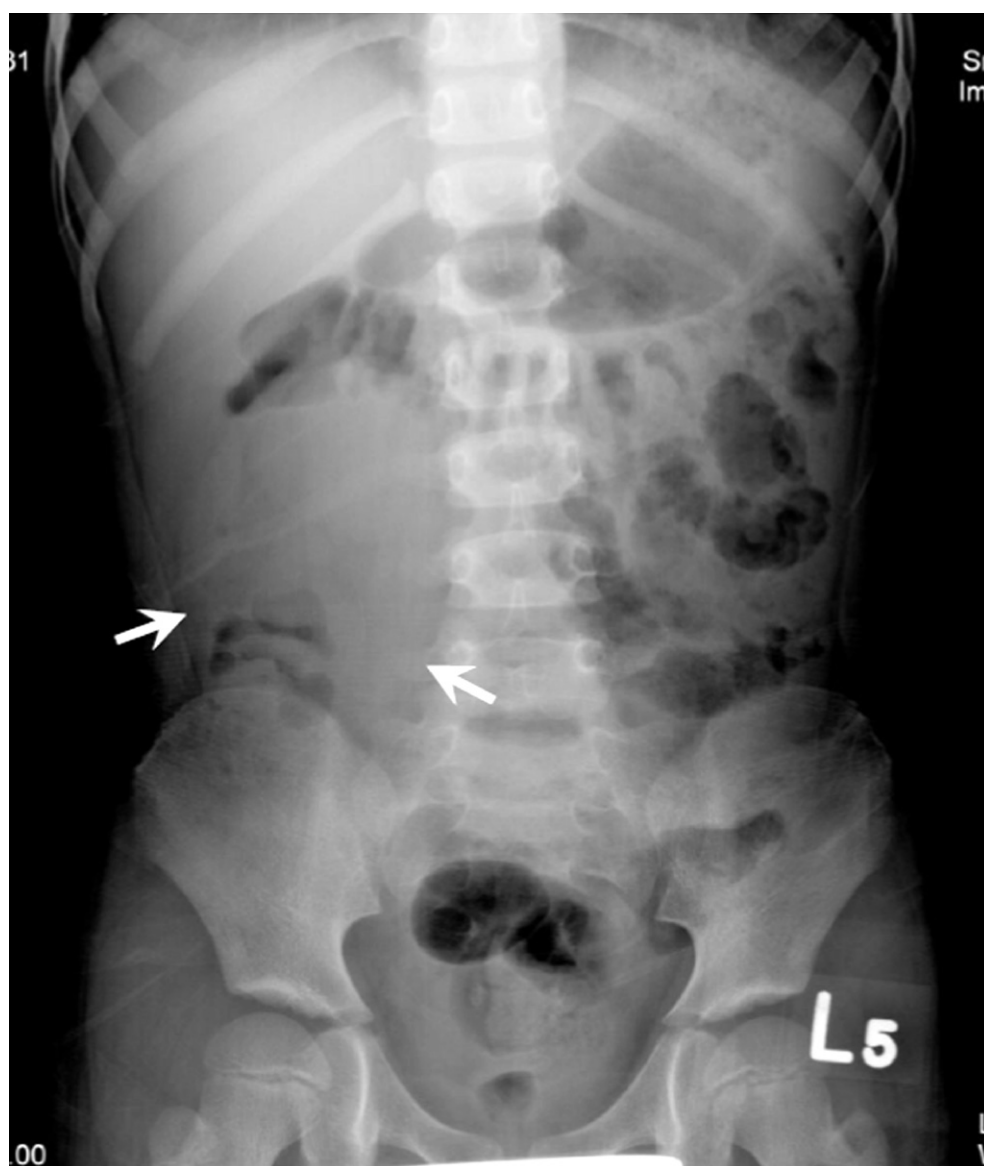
A supine plain radiograph of abdomen demonstrated a focal mass-like lesion with soft tissue density (white arrows) over the right lower abdomen.
